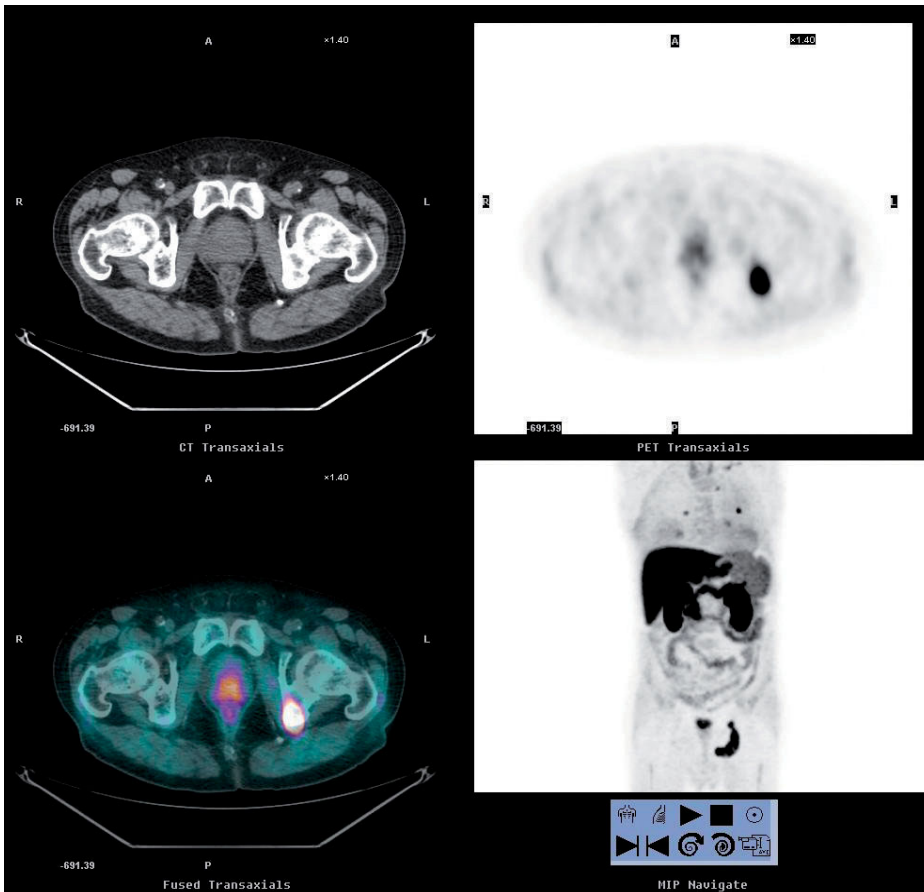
CT-PET with choline. In addition to pathologic hyperaccumulation in the prostate (due to tumor), tracer uptake (metastasis) can also be visualized in the left ischiopubic ramus and in both lungs
